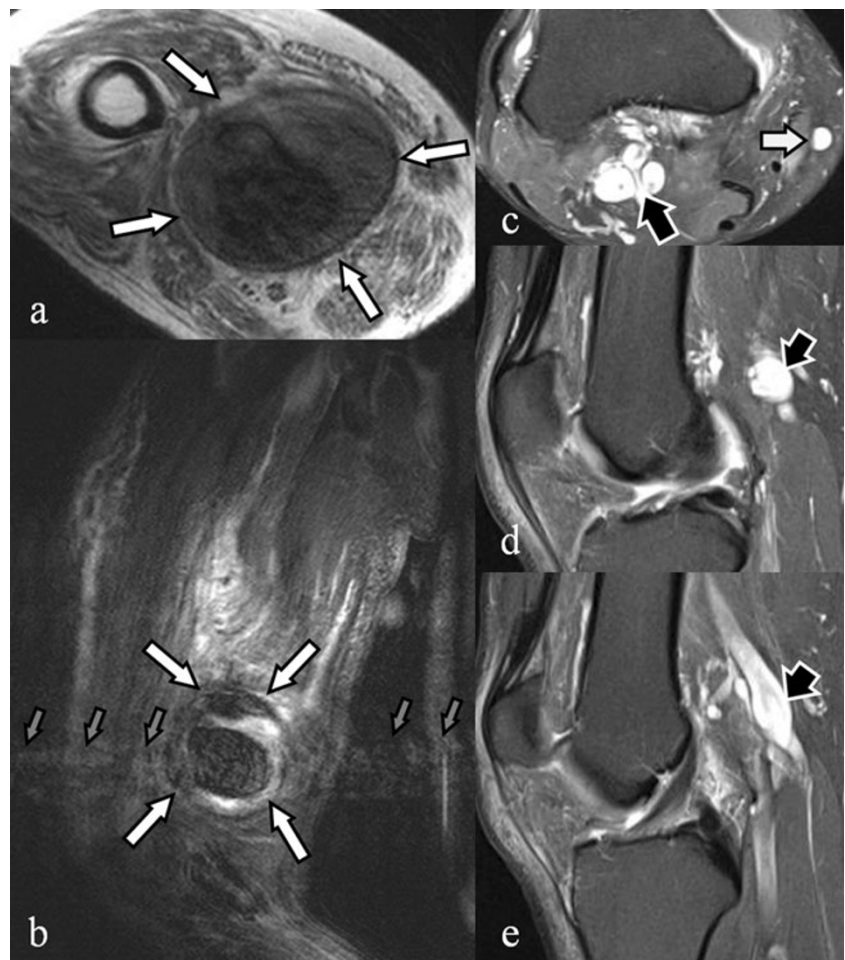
Popliteal artery aneurysm*: the axial (a) T1-weighted and the sagittal (b) T2-weighted GRE images show a popliteal aneurysm with thrombus and rim-like calcifications. The blood flow creates an artefact (grey arrows) that helps in the diagnosis. *Popliteal vein's varices*: the axial (c) and coronal (d, e) fat saturated proton density weighted images demonstrate lobulated cystic lesions (black arrows) in continuity with the popliteal vein consistent with popliteal vein varices. White small arrow in (c) points to the dilated great saphenous vein
